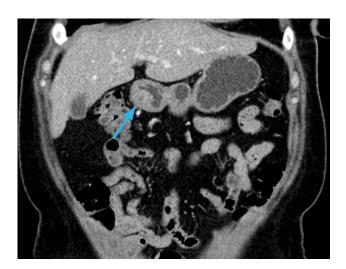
Abdominal CT scan 10 weeks after the drainage.
